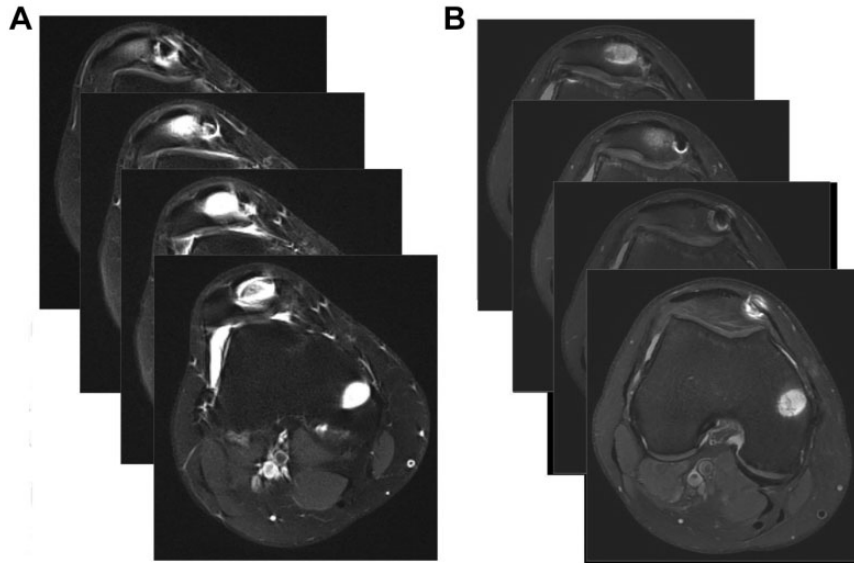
(A) Preoperative and (B) postoperative axial magnetic resonance imaging scans of the same knee. The measurements were performed at the 4 most proximal axial slices visualizing the trochlear cartilage: level 1: 0-3.5 mm from the proximal border of the trochlea; level 2: 4-7.5 mm; level 3: 8-11.5 mm; and level 4: 12-15.5 mm. The artifact in the patella is a titanium suture anchor after 2 previous attempts of reconstruction of the medial patellofemoral ligament.
